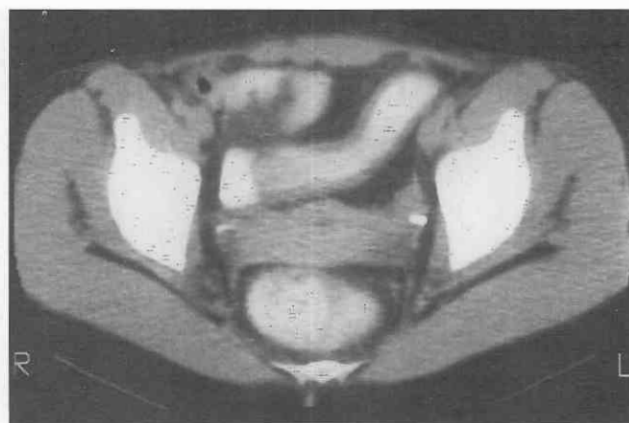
Ulcerative colitis. CT scan through the pelvis in a patient with ulcerative colitis demonstrates mild thickening of the sigmoid colon.
